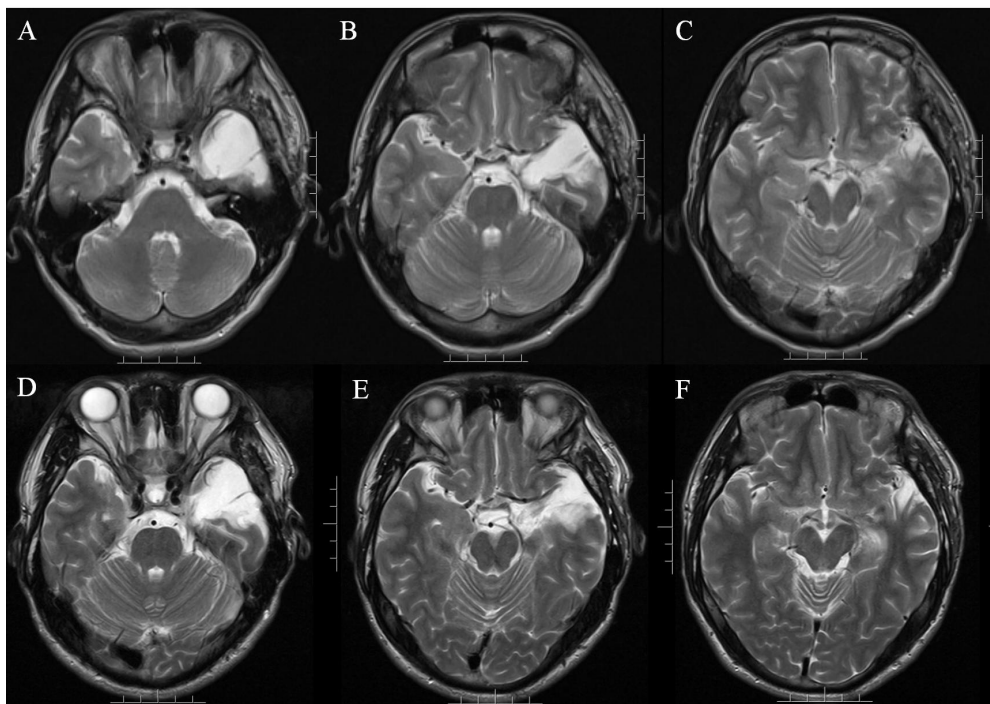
The patient underwent a follow-up head MRI on 2024-10-28, where T2-weighted images showed the surgical resection area (Fig. A, B, C). A subsequent follow-up MRI on 2024-12-06 (3 months post-surgery) revealed a clearer depiction of the resection area, with enhanced visibility of the left middle cerebral artery flow void in the surgical site (Fig. D, E, F). MRI = Magnetic Resonance Imaging.
